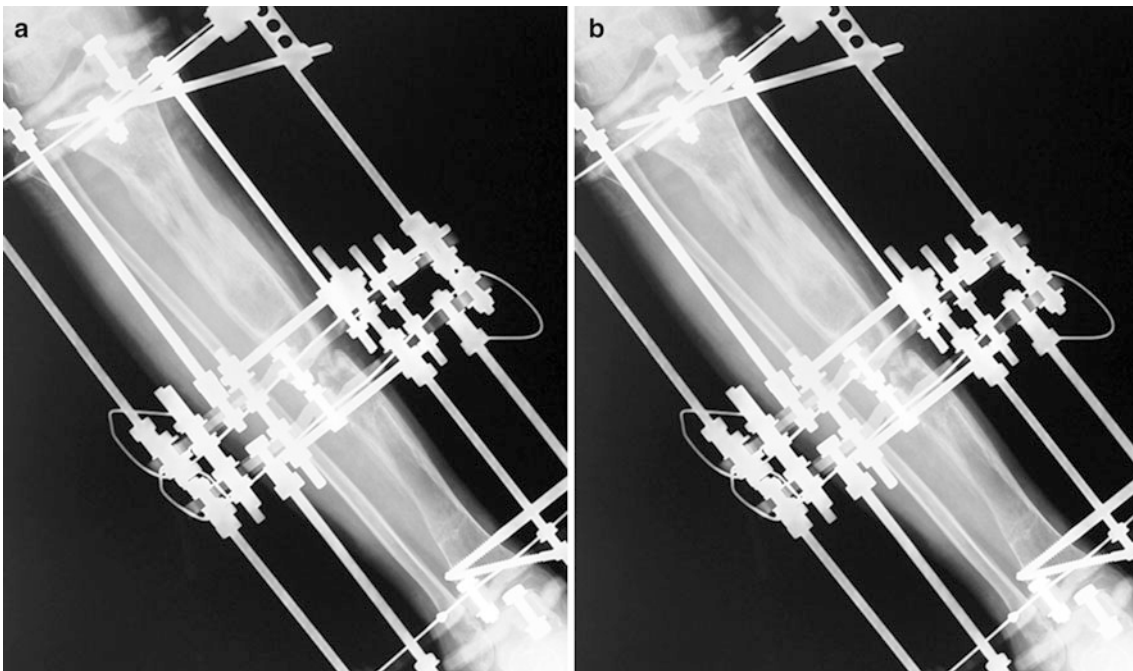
AP (a) and Lat (b) radiographs 8 months after operation. Bone grafting performed due to delayed union. Frame is also limiting further compression
